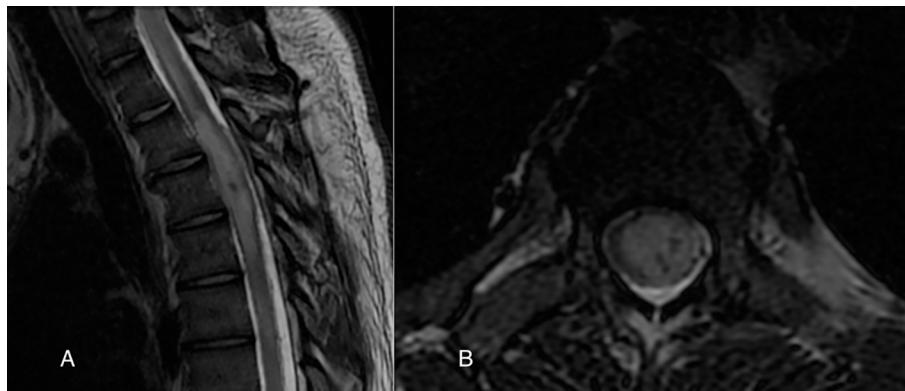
Patient 3 preoperative images: Sagittal (A) and axial (B) T2-weighted spinal MRI show inhomogeneous thoracic intramedullary mass with perilesional edema.
